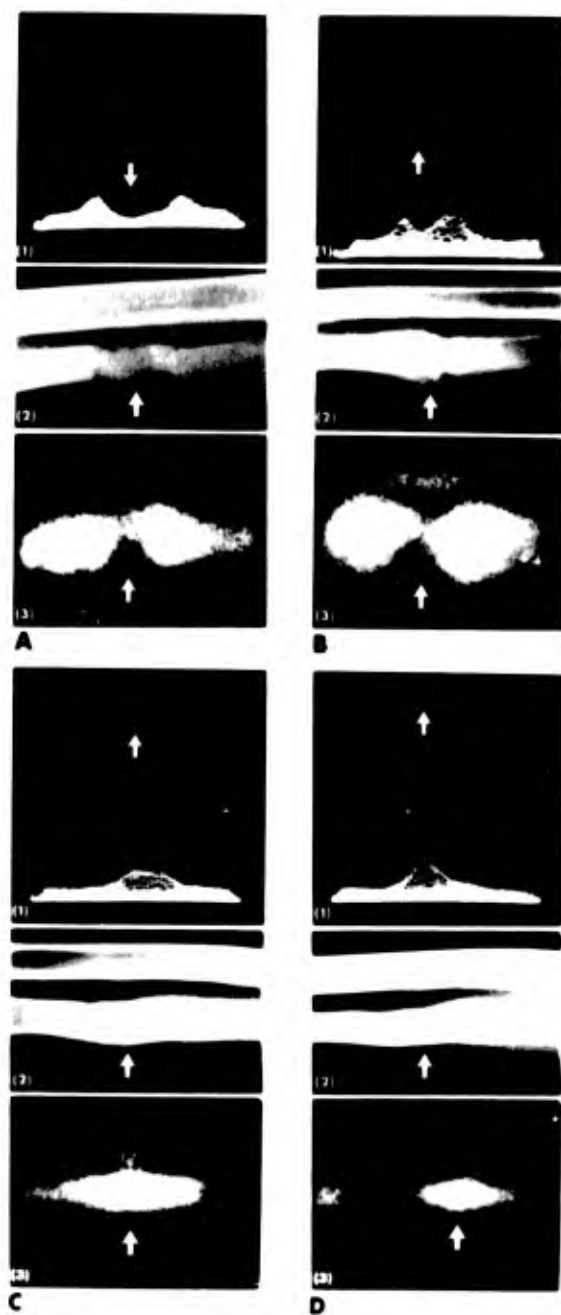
Radiographic and radioisotope computer and scan analysis of a healing bone graft. Initially (A), the graft is minimally viable. The scan A3 reveals little activity of the graft (arrow) which on the computer display is represented by a valley (A1, arrow). As healing progresses, the areas of junctional activity on the scan coalesce (B3, C3, D3) into one "hot spot." The computer display (B1 and C1) reveals coalescing of the two peaks into one, which later narrows (D1).
